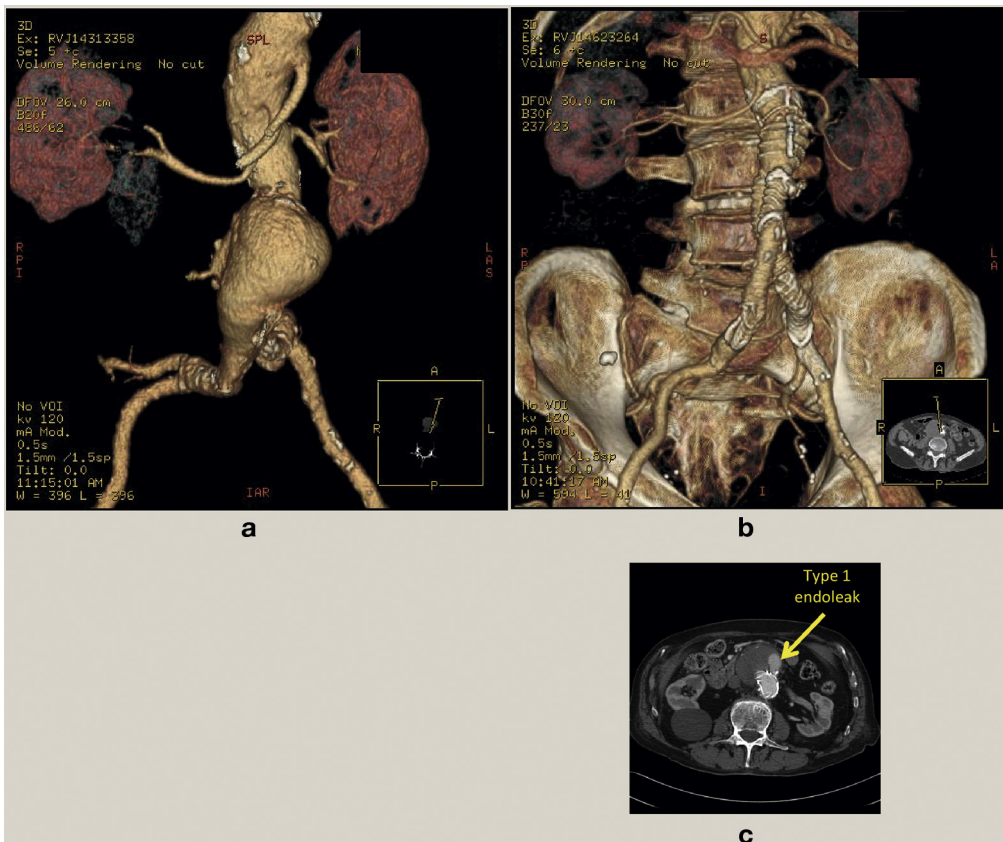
(a) CT angiogram of a patient with a complex abdominal aortic aneurysm. (b) shows the result following endovascular repair. (c) shows contrast within the sac arising from a type I endoleak.
